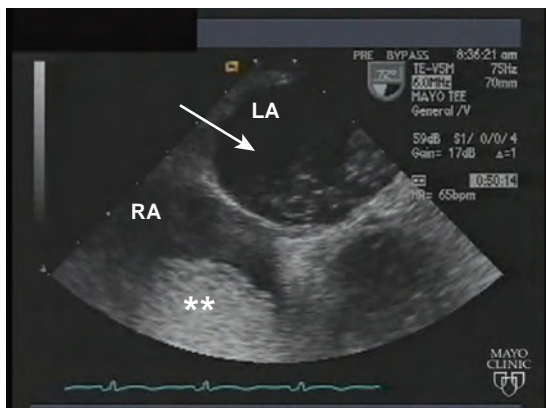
Transesophageal image from the midesophagus at 72 degrees focusing on the interatrial septum. Agitated saline (double asterisks) is being used for contrast and can be seen in the right atrium (RA). With the release of a Valsalva maneuver, the contrast is seen to enter the left atrium (LA) through a small patent foramen ovale.
